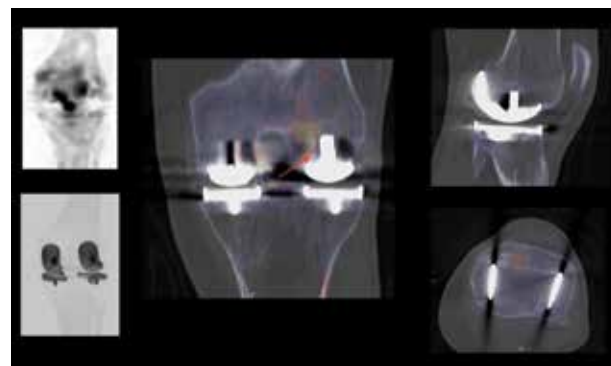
xSPECT Bone and fused images also show mild increases in uptake in the medial margin of the lateral femoral condyle at the junction of the edge of the femoral component of the lateral hemiarthroplasty prosthesis, which suggests stress reaction due to overload at the insertion of the anterior cruciate ligament. The fused images show normal position and alignment of the femoral and tibial components of both hemiarthroplasty prosthesis with no periprosthetic osteolysis or fractures, no lucent zones between the tibial and femoral component stems and the bone. The tibial plates and the femoral condylar component of the prosthetic joints appear properly fixed without dislocation, mal-alignment or subluxation. The CT MIP image (left lower corner) also show both hemiprosthesis to be properly positioned and aligned. This suggests an absence of prosthetic loosening, malpositioning or periprosthetic fracture.
